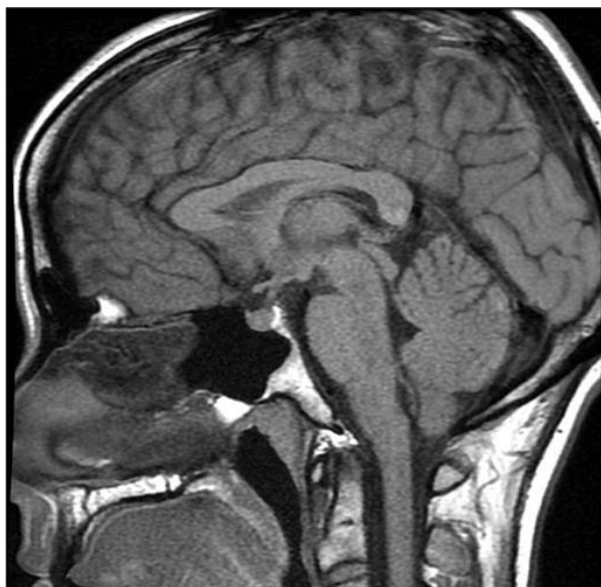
Normal MRI study of the pituitary gland
